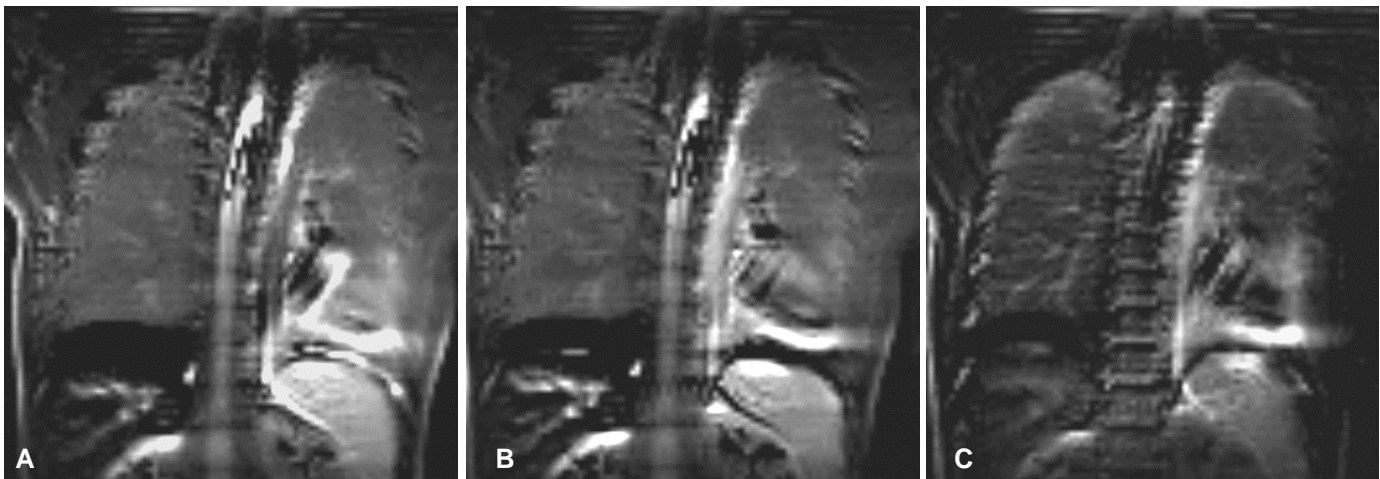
Oxygen-enhanced MRI of a 24-year-old volunteer acquired with respiratory triggering using PACE (A), respiratory triggering using a respiratory belt (B), and during breathhold. The image obtained with PACE shows the best visualization of the ventilated lung.
